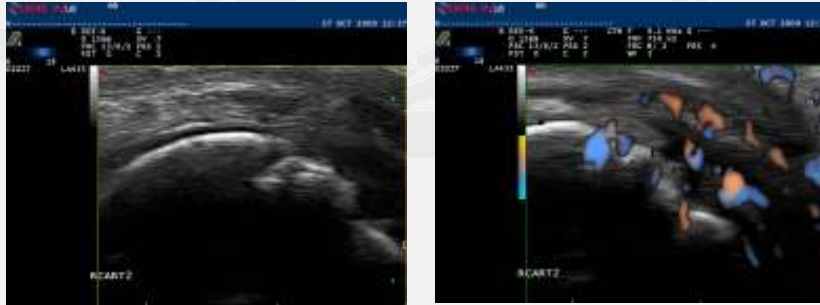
Grayscale and power Doppler ultrasound images of synovial hypertrophy in patients with RA
